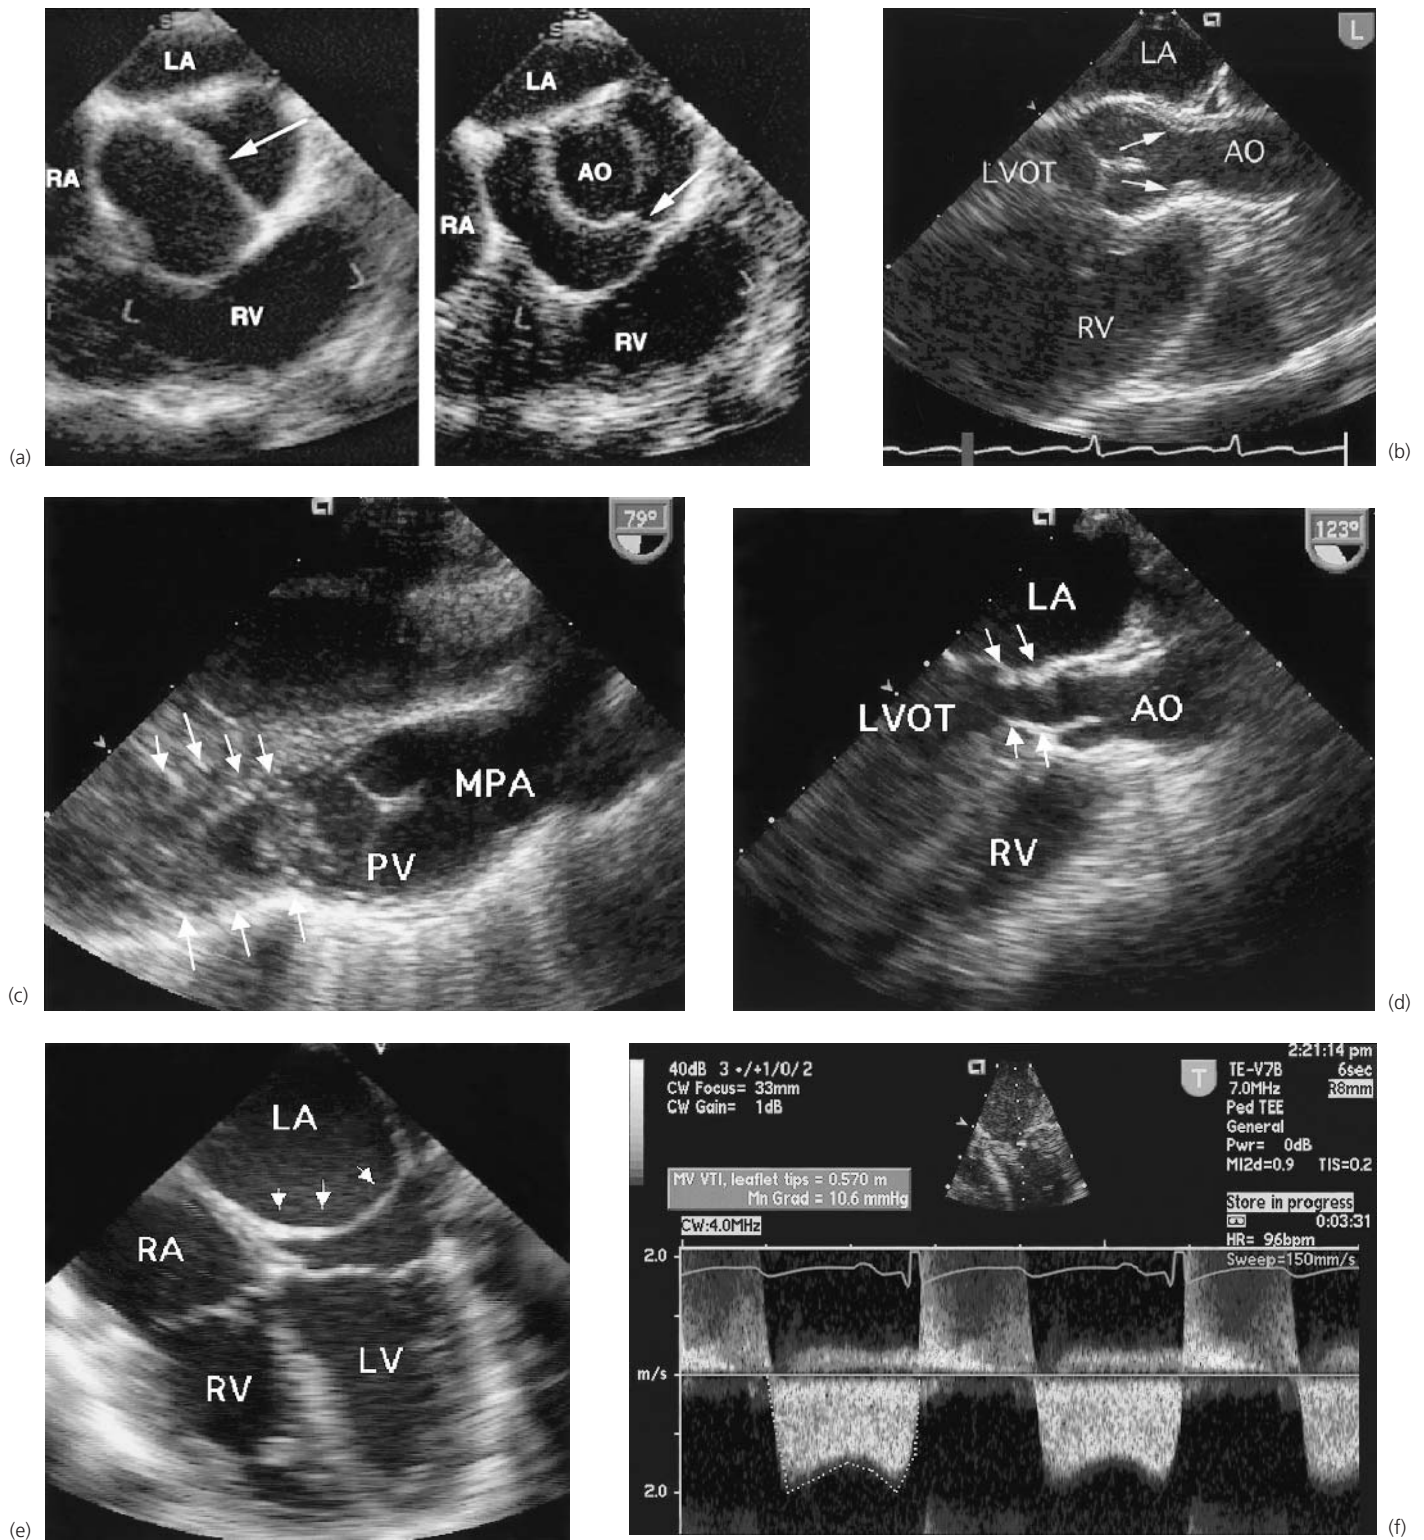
Echocardiographic images of obstructive lesions. (a) Bicuspid (bicommisural) aortic valve. Left panel showing diastolic frame of bicuspid aortic valve in the short axis view (arrow points to the coaptation site). Right panel depicting typical “fish mouth” appearance of bicuspid aortic valve in systolic frame. The region of commissural fusion is noted by the arrow. (b) Supravalar aortic stenosis. Aortic long axis view demonstrating the typical hourglass deformity that accounts for narrowing of the sinotubular region (arrows) in a patient with supravalar aortic stenosis. (c) Double chamber right ventricle. Long axis view of pulmonary outflow tract in a patient with right ventricular obstruction displaying severe hypertrophy of muscle bundles located below the level of the pulmonary valve. (d) Subaortic stenosis. Two-dimensional echocardiographic appearance
